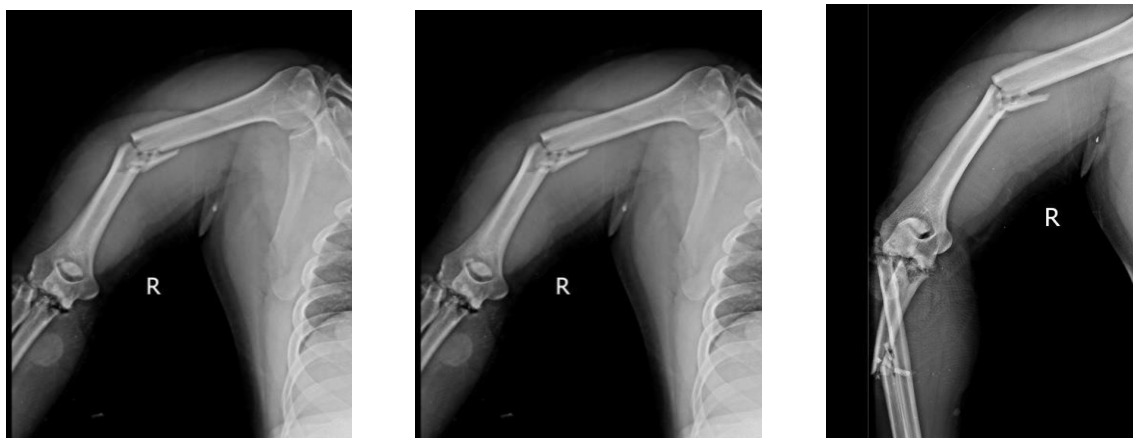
Preoperative x-rays of the patient.
